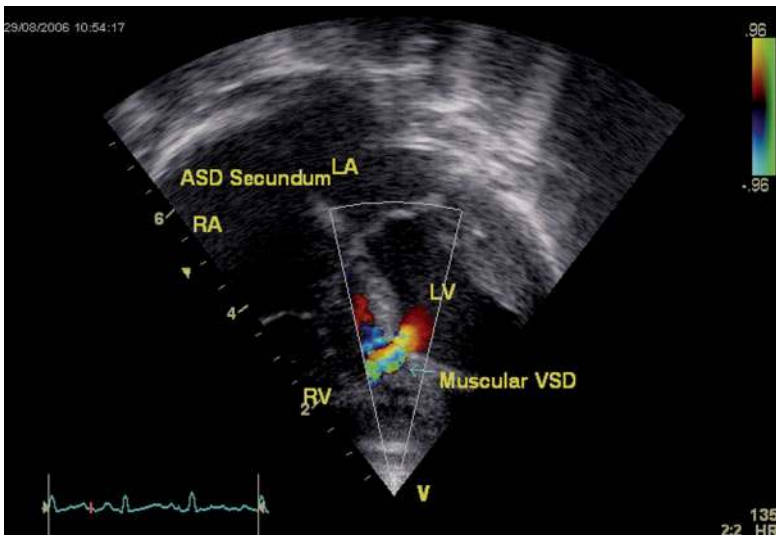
Apical four-chamber view with color flow Doppler demonstrating a mid-muscular ventricular septal defect (VSD)
